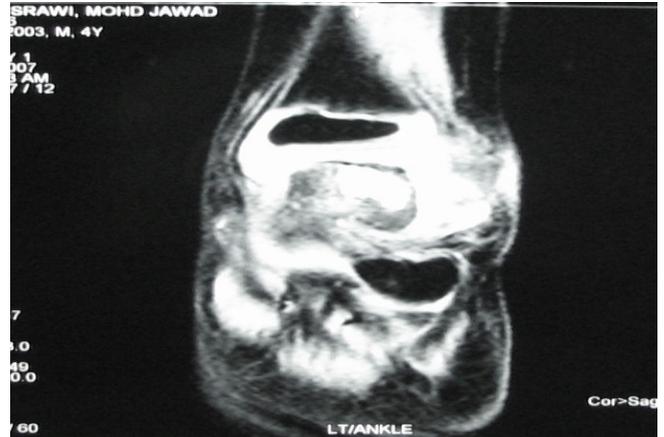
Edema around talus bone and increased ankle joint synovial fluid in MRI.
